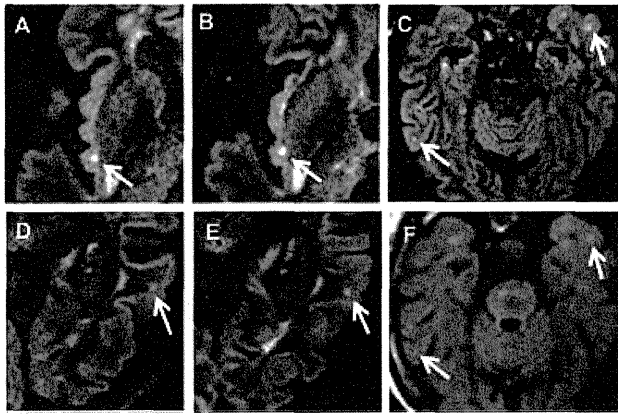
Head MR images in a 77-year-old woman with sporadic AD (Patient 1). DIR image shows small high signal foci in the right insula and left temporal cortices (arrows in A, D). One year later, these lesions still remained (arrows in B, E) and additional lesions appeared in the bilateral temporal lobes (arrows in C, F).
